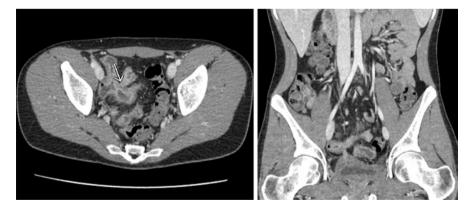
Axial & Coronal CT images demonstrating Crohn's disease associated enterovesical fistula. Note terminal ileitis, stricture and entero-enteric fistula on axial views
